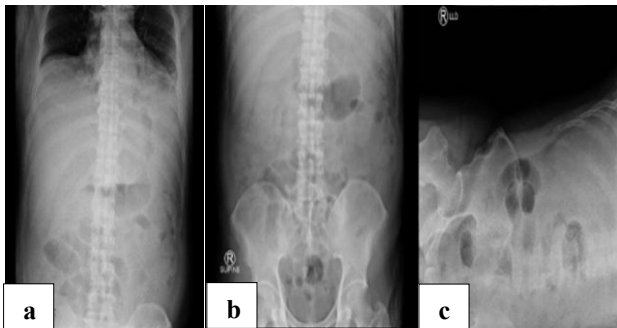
(a-c): Plain abdominal radiography (BNO three-position) result of the patient, showing dilated small bowel loops with a herringbone appearance and air distribution reaching the distal colon.
